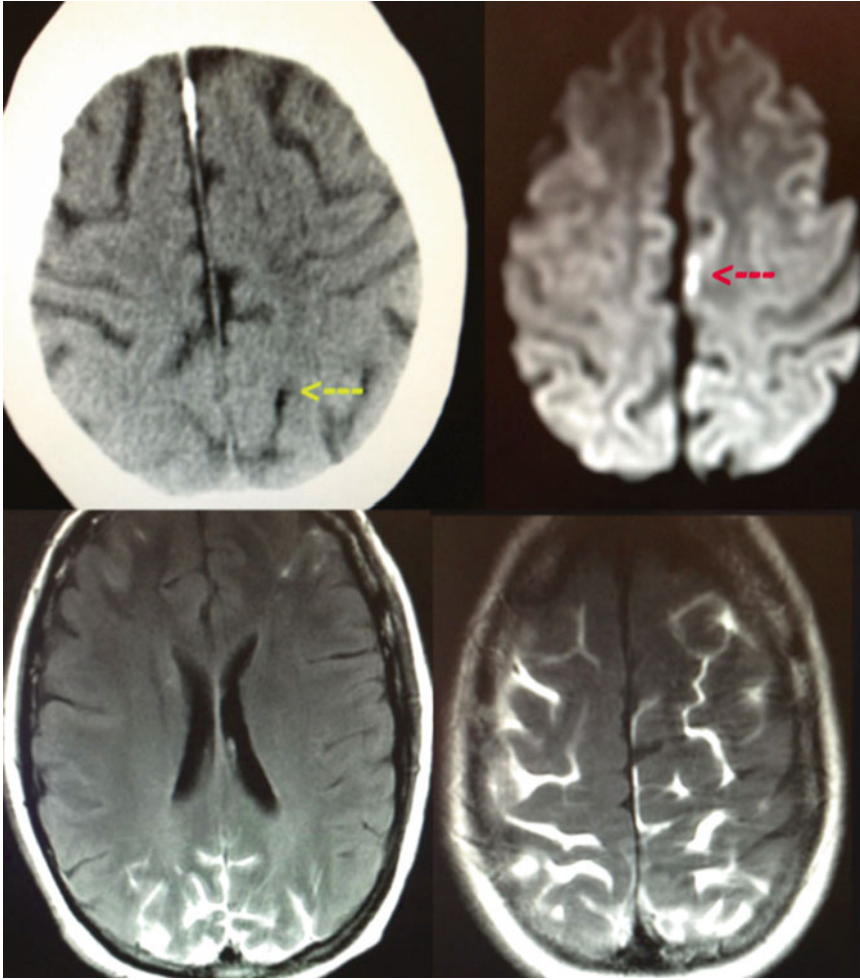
Air emboli appear on CT as *black spots* (upper left) with negative Hounsfield numbers; this patient recovered her vision with the use of a hyperbaric chamber
